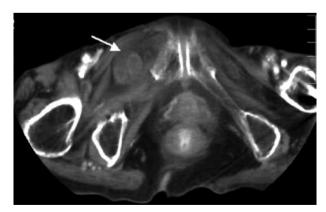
The CT scan of patient 2 showed incarcerated bowel in the right obturator hernia (arrow)
